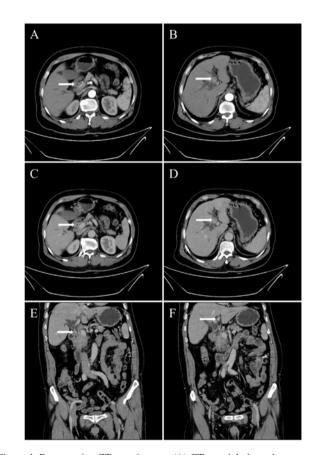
Preoperative CT scan images. (A) CT arterial phase demonstrated moderate enhancement of the common bile duct wall. (B) CT arterial phase demonstrated moderate enhancement of the left hepatic duct wall. (C) CT venous phase demonstrated moderate enhancement of the common bile duct wall (horizontal position). (D) CT venous phase demonstrated moderate enhancement of the left hepatic duct wall (horizontal position). (E) CT venous phase demonstrated moderate enhancement of the common bile duct wall (coronal position). (F) CT venous phase demonstrated moderate enhancement of the common bile duct wall (coronal position). (F) CT venous phase demonstrated moderate enhancement of the left hepatic duct wall (coronal position). White arrows indicate location of the lesion.
